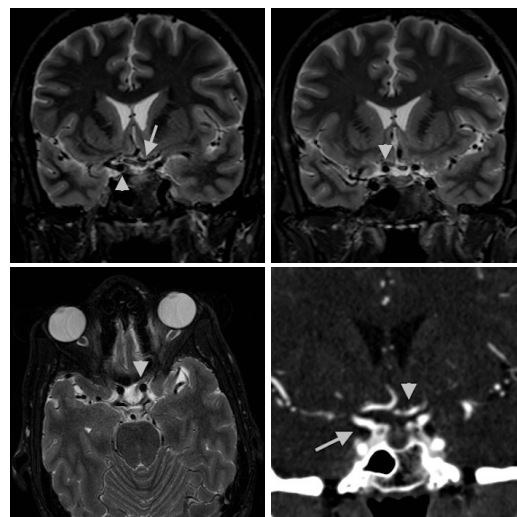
A. (Top Left) Coronal T2 MRI: Arrowhead showing right cavernous carotid displacing optic chiasm superiorly. Arrow highlighting left ACA displacing the left portion of the optic chiasm inferiorly. Also note focal hyperintensity in the right chiasm. B. (Top Right) Coronal T2 MRI: Arrowhead showing displacement of optic chiasm superiorly by supraclinoid cavernous carotid. C. (Bottom Left) Axial T2 MRI: Arrowhead showing medial displacement of left optic nerve. D. (Bottom Right) Coronal MRA: Arrowhead highlighting course of ACA. Arrow showing the internal carotid artery.
